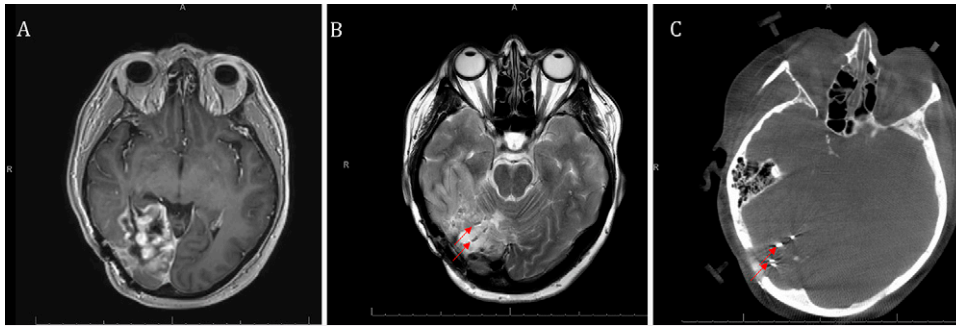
Imaging before LITT. A: Axial postcontrast T1-weighted MRI showing recurrence of right occipital meningioma. Axial T2-weighted MRI (B) and computed tomography (C) showing cesium brachytherapy implants in prior resection bed. *Red arrows* point to cesium seeds.
